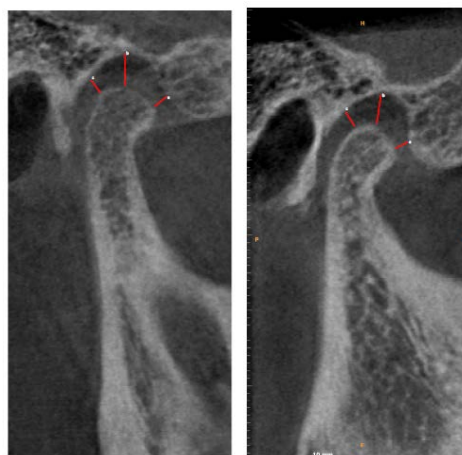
Limited cone beam computed tomography images of temporomandibular joint a. Anterior joint space (AS), b Superior joint space (SS), C Posterior joint space
